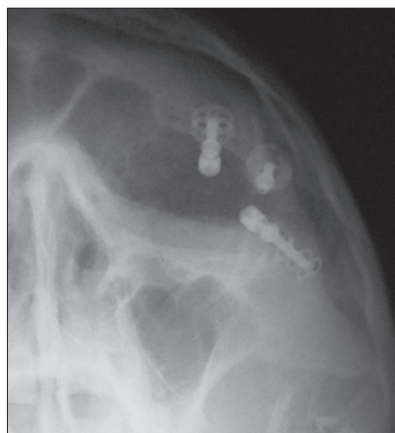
Waters projection radiography with placed implants
